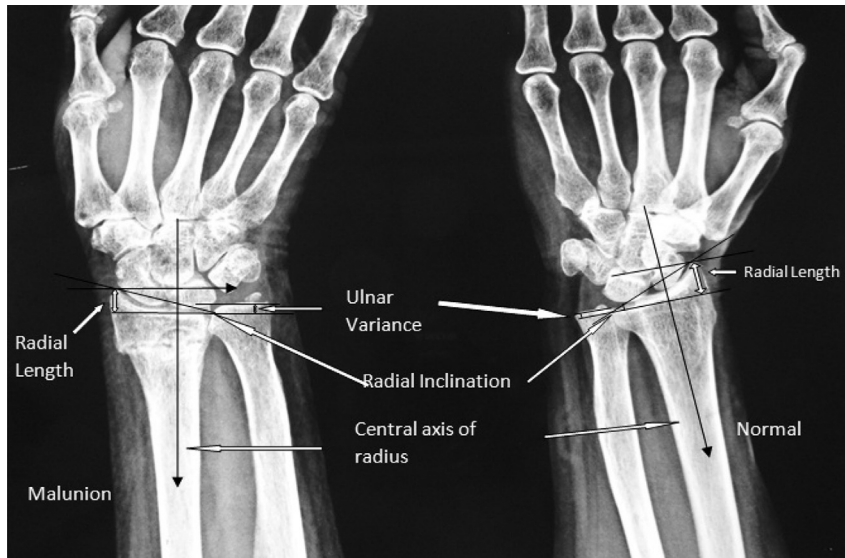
Radiograph of patient hands with wrist <50 years of age (PA view).
